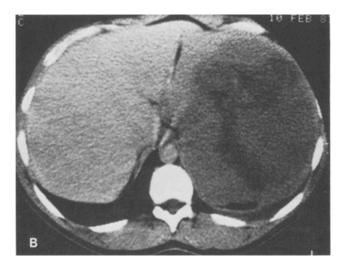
Radionuclide scan of solitary non-parasitic cyst, upper pole. B. Computed tomographic scan showing massively enlarged spleen (on left) with some central cavitation. Diagnosis, histiocytic lymphoma. C. Computed tomographic scan showing large cystic lesion of spleen, with some irregular intracystic projections. Diagnosis, metastatic papillary ovarian adenocarcinoma.
